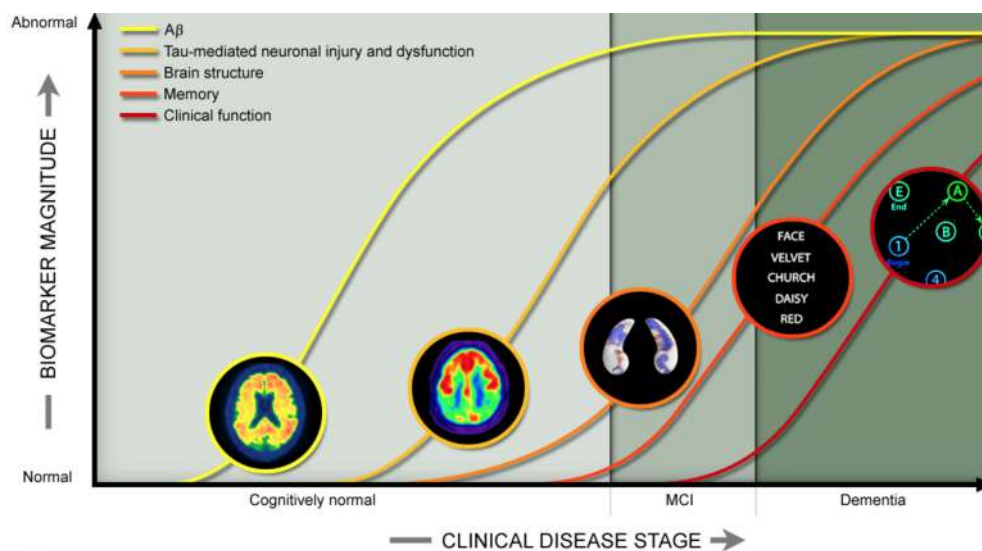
Curves of changes caused by five dementia biomarkers: Amyloid beta scan detected in cerebrospinal fluid and amyloid PET scan (yellow line); neurodegeneration detected by the increase, in cerebrospinal fluid, of tau species and synaptic dysfunction, measured by FDG-PET (dark yellow line); cerebral atrophy and loss of neurons measured by magnetic resonance in particular in hippocampus, caudate nucleus and medial temporal lobe (orange line); memory loss measured by cognitive assessment (dark orange line); general cognitive decline measured by cognitive assessment (red line). The first three lines are given by biomarkers that can be observed before a diagnosis of dementia. The last two lines are the classic indicators of AD diagnosis [6].
